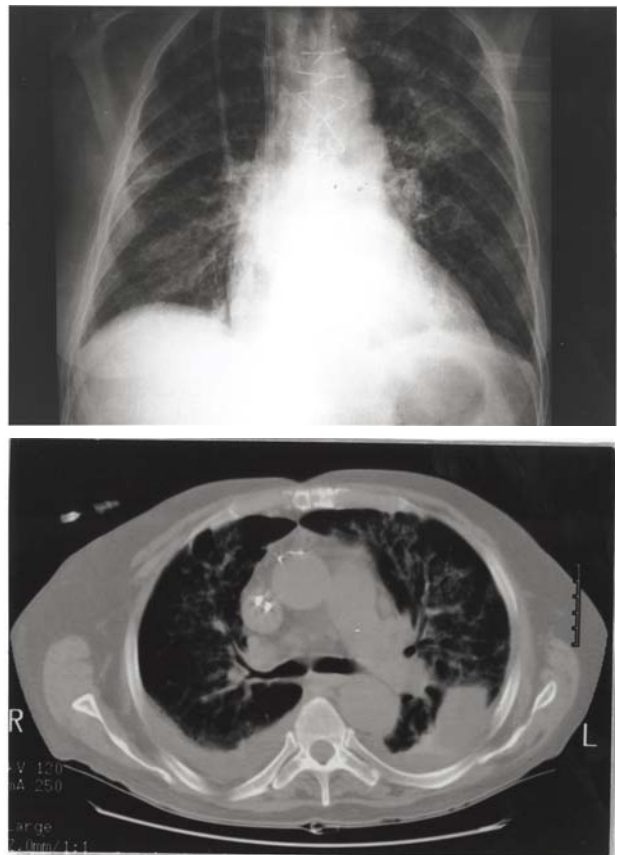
Radiograph (A) and CT (B) of the chest; significant findings are bilateral interstitial alveolar infiltrates and minimal pleural effusion. The tip of the hemodialysis access catheter is visible in the superior vena cava.
